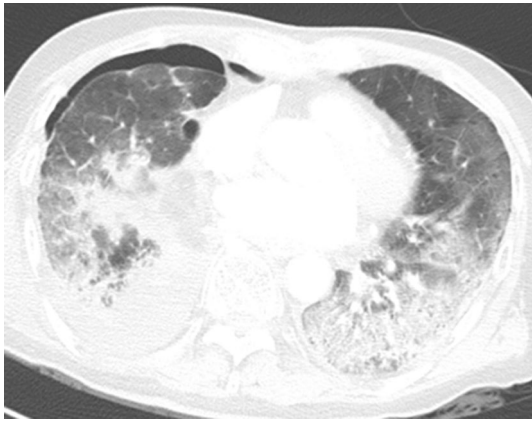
Acute respiratory distress syndrome in a 78-year-old man treated with right middle and lower lobectomy for adenocarcinoma. Axial CT image on POD 21 shows extensive ground-glass opacities and consolidations in dependent lung. Small right pneumothorax is also noted. PaO₂/FiO₂ ratio of this patient is 128 mmHg
